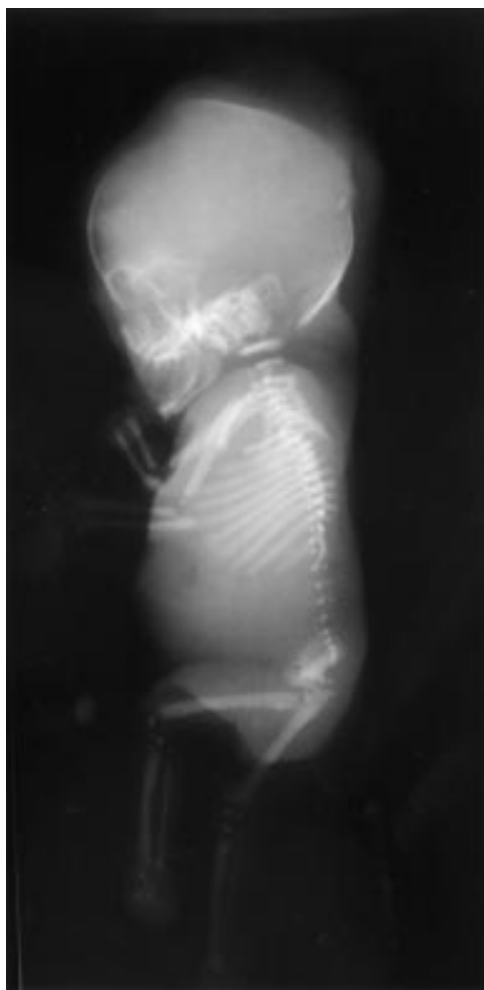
Radiograph of fetus showing punctate calcification of epiphyseal areas and stippling of carpal and tarsal bones.
